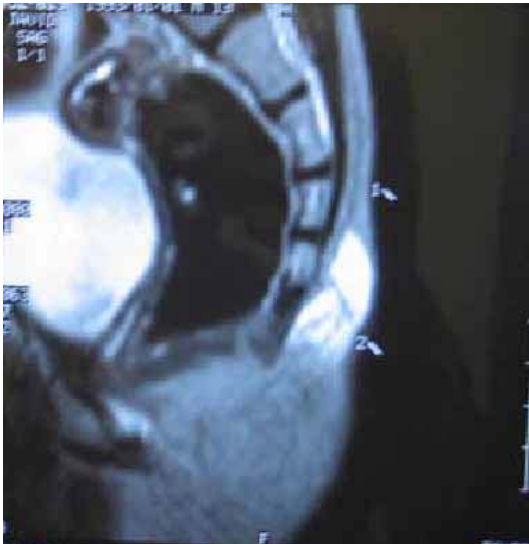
represents a sagittal MRI image of the sacral bone of a 6 years boy after insertion of two plastic cannula showing the direction of the sacral hiatus and showing the direction of trans-sacral route. After preparation and local anesthetic
